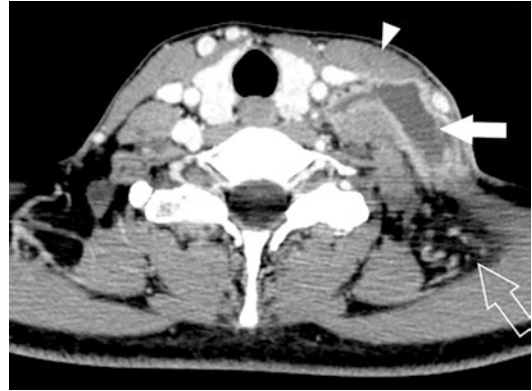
Tuberculous neck abscess from ruptured tuberculous lymphadenitis. Axial contrast-enhanced CT image shows a loculated rim-enhancing fluid collection in the left posterior cervical space (arrow). The patient had US imaging of the neck 6 weeks before CT, which showed left cervical lymphadenopathy with internal necrosis at the same area as an abscess (see Fig. 1b). Note that the adjacent sternocleidomastoid muscle appears normal (arrowhead). Minimal fat stranding is present in the posterior cervical space (open arrow)
